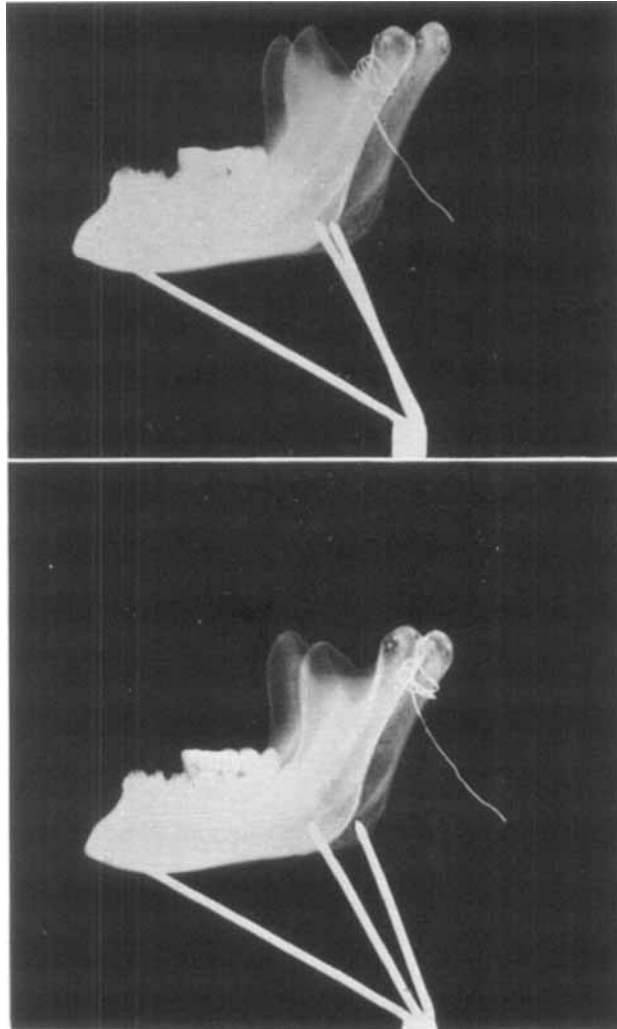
Roentgenograms of the mandible at 5° left rotation round the vertical axis (top) and right rotation (bottom).
